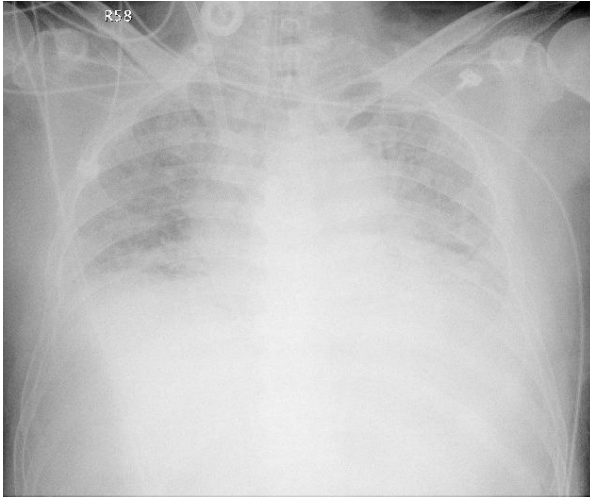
Chest roentgenogram on post-contrast day 2: Endotracheal intubation and V-V ECMO implantation were instituted.
